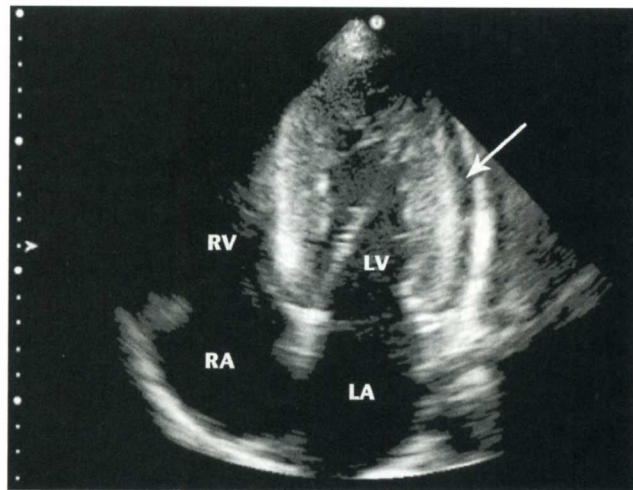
Concentric hypertrophy. Apical four-chamber view demonstrates symmetrical thickening of the left ventricular wall. A small pericardial effusion is noted adjacent to the left ventricle (arrow). LA = left atrium, LV = left ventricle, RV = right ventricle, RA = right atrium. (Courtesy of Hennepin County Medical Center)
